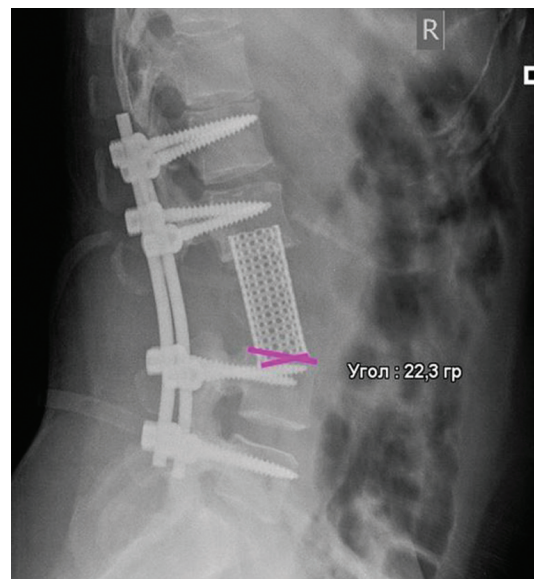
Lateral radiograph of the lumbar spine showing condition after resection of hemangioendothelioma of the L3 vertebra; angle of 22° discrepancy between the contact surfaces of the prosthesis and the endplate of the L3 vertebra
